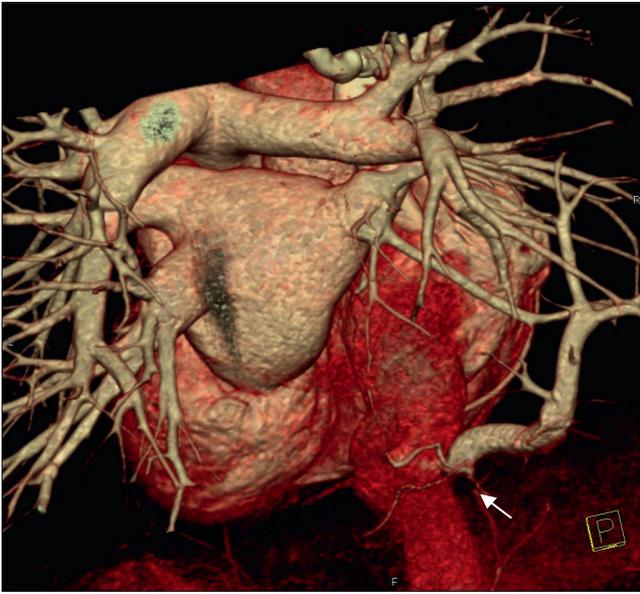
Cardiovascular computed tomography. Reconstruction of heart and great vessels. Anomalous pulmonary vein draining into the inferior vena cava (arrow)
